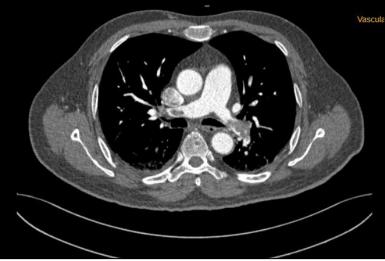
CT pulmonary angiography, axial image shows near complete occluding thrombus in right and left main branches of pulmonary artery (seen as hypodense filling defect)
